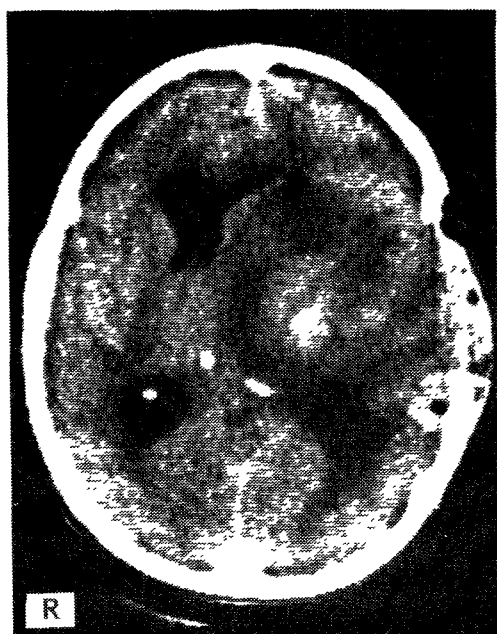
Patient 2: CT scan at level of the temporal craniectomy after replacement of bone flap.
